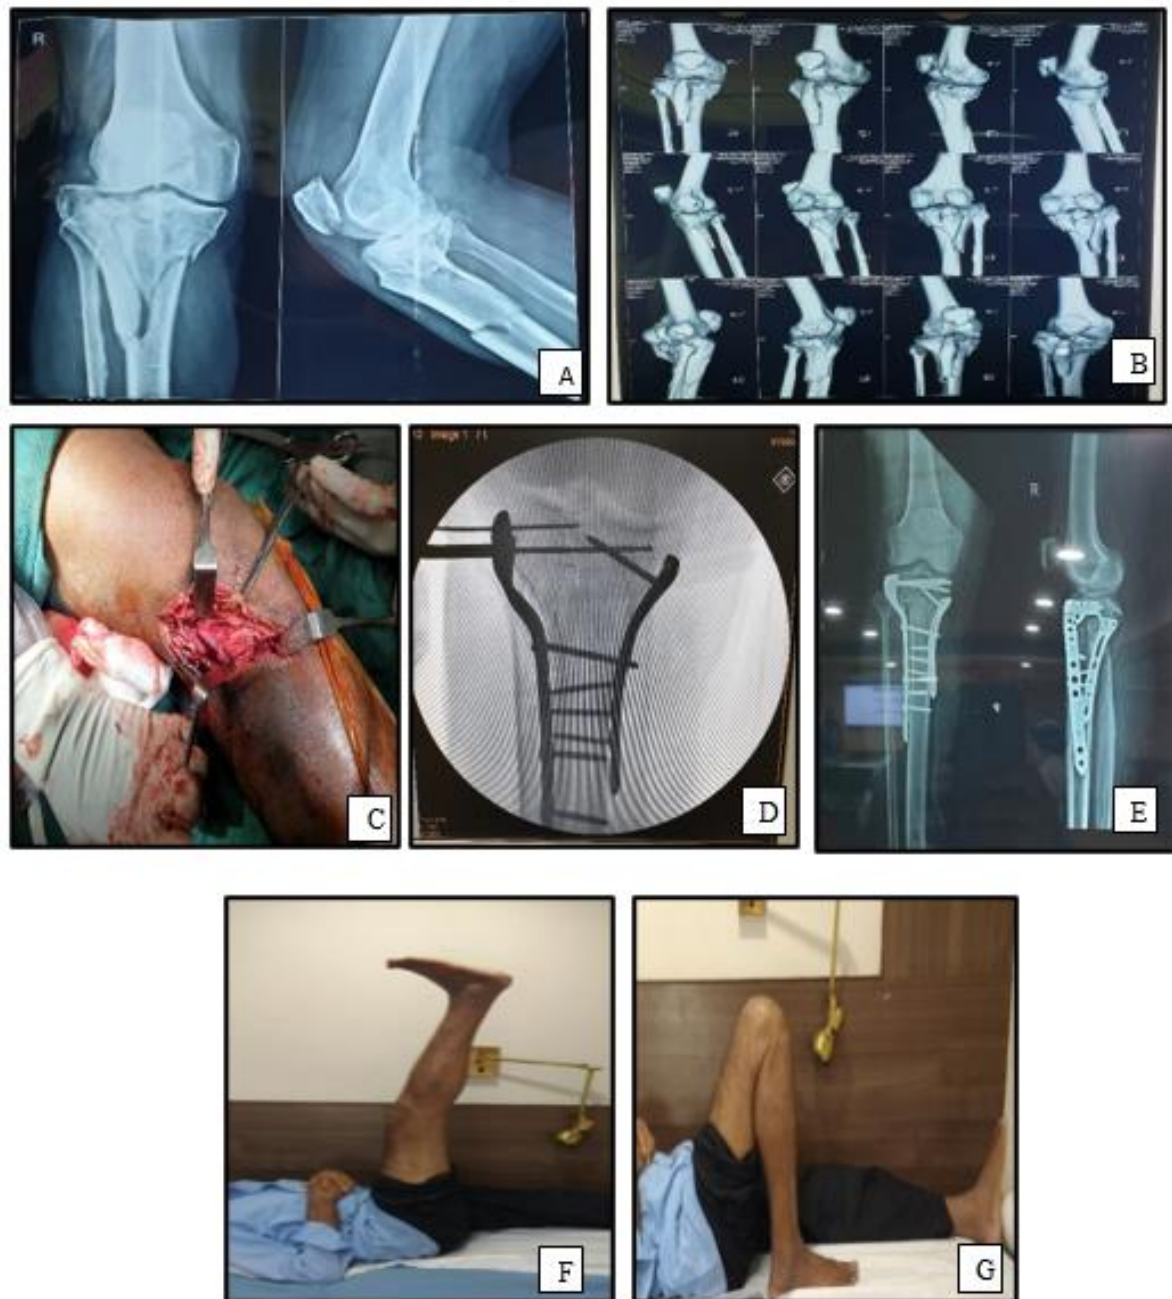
(A) Pre-op X-ray showing an intra-articular bicondylar tibial plateau fracture; (B) 3D reconstruction CT scan of the tibial plateau fracture; (C) Intra-op anterolateral approach to the knee; (D) Intra-op fluoroscopic view showing fracture reduction and plate placement with appropriate screw combination; (E) Immediate post-op X-ray; (F) Knee extension at final follow-up; (G) Knee flexion at final follow-up
